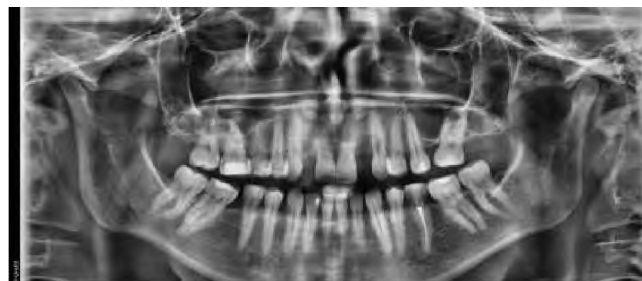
№2. Panoramic X-ray patient at the time of treatment.
